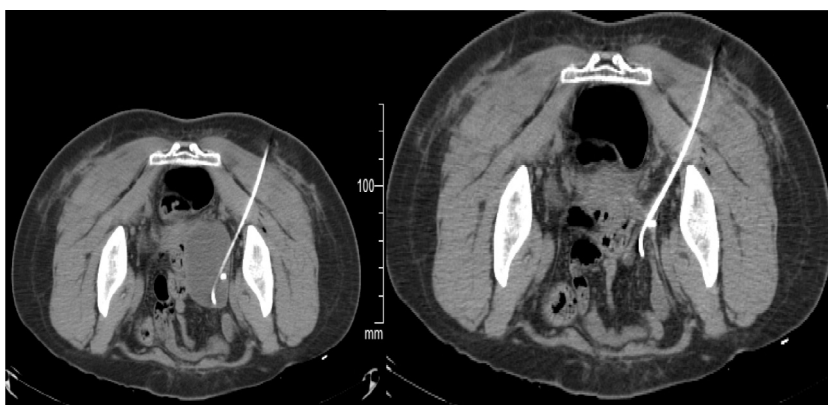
38 Year old woman presented with diffuse pelvic pain dysurea with fever of 37.5 °C and Leukocytosis ultrasound (not shown) depicted localized pelvic collection confirmed by CT, No safe window to access the collection because of bowel loops and urinary bladder anteriorly and iliac bone and sacrum posteriorly, CT guided transgluteal approach with the single step tandem trocar technique for placement of 8 Fr Flexima catheter. (b) After complete aspiration of the collection. Catheter was left in place for 7 days and catheter output reduced to less than 10 ml/day then removed.
